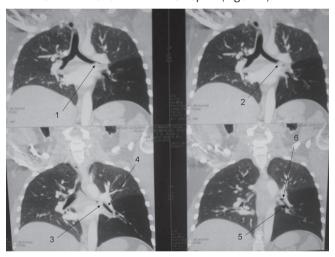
Preoperative chest computed tomography coronal sections: 1-2-3) dating back to the left main bronchus in the secondary hull EBL 4-5) of the lower lobe bronchus open 6) open the upper lobe bronchus
